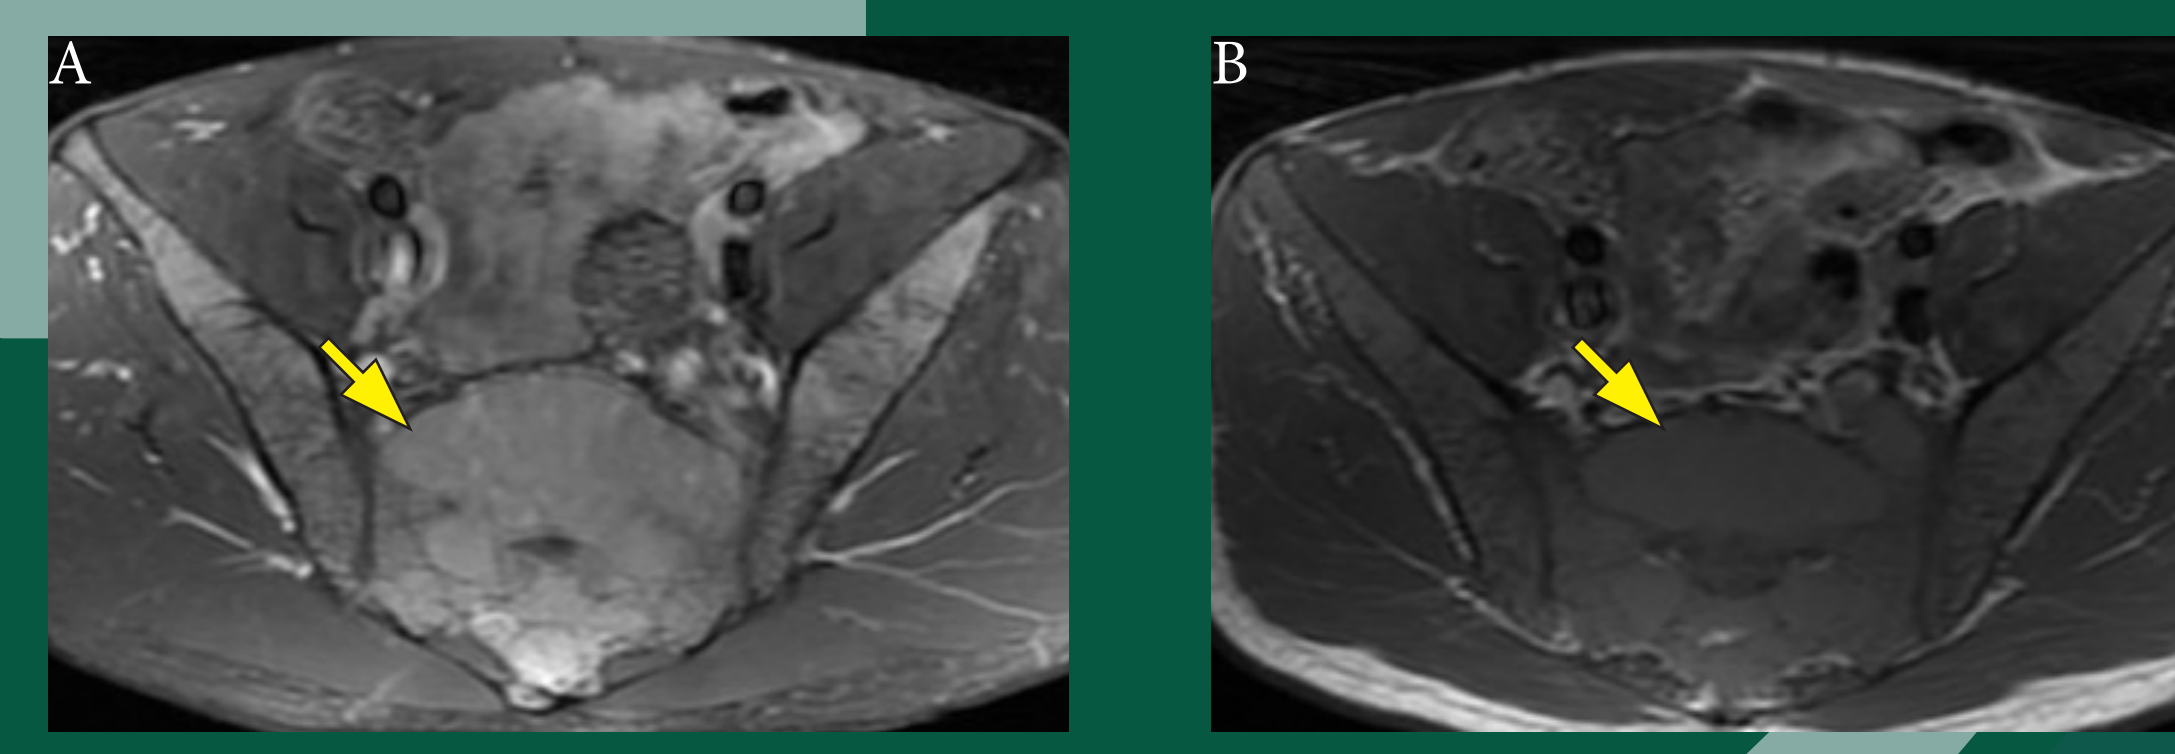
MRI of the lumbosacral spine. T1 (A-B) and T2 weighted (C) coronal projections demonstrating a presacral mass with isointense T1 and hyperintense T2 signal characteristics with enhancement on postcontrast images.
